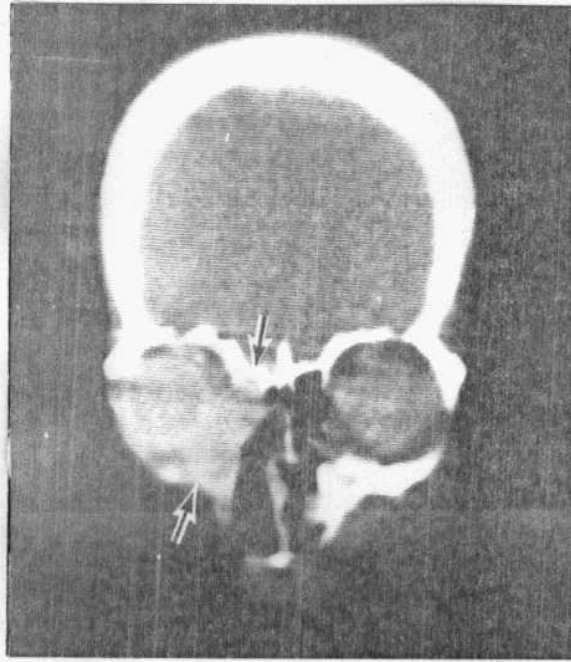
Coronal CT scan reveals destructive lesion of right orbital floor, maxilla, and ethmoid. Mass has involved orbital structures, pushing globe laterally. Squamous cell carcinoma.
